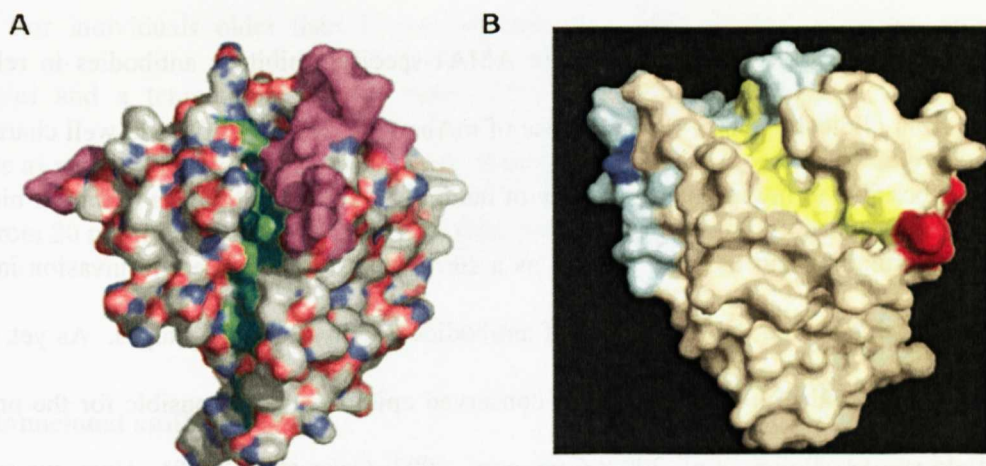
X-ray structure of *P. falciparum* AMA1 domains I and II showing the hydrophobic trough and binding sites of mAb 1F9 and mAb 4G2. (A) Base of the hydrophobic trough indicated in green, disordered loops in purple (Bai et al. 2005), (B) residue 197 that is critical for mAb 1F9 binding shown in blue, mAb 4G2 critical residues in red, and the hydrophobic cleft is in yellow (Coley et al. 2006).
